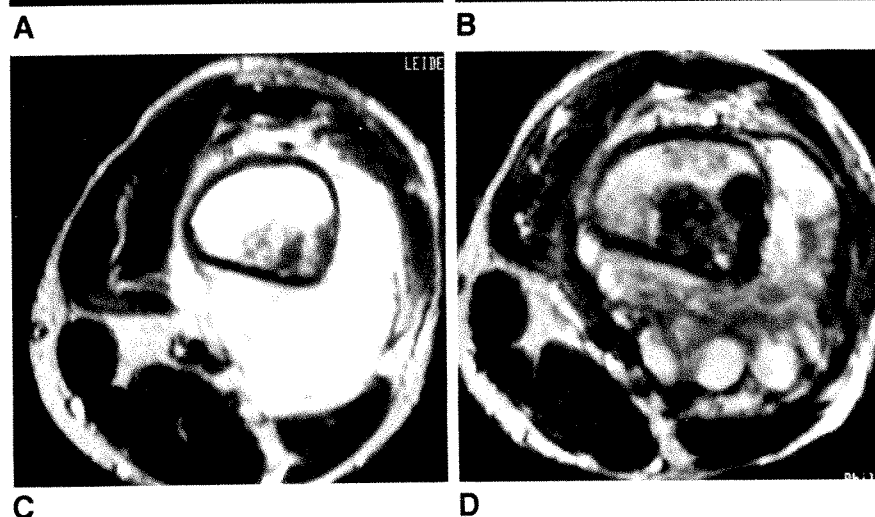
Osteosarcoma of the femur (case 12) on T2-weighted MR images (2000/100).
